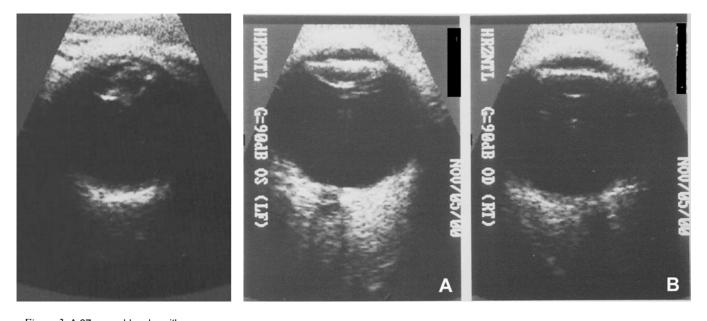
Ocular sonography of a 28-year old male, with a history of blunt trauma to the right eye 6 years earlier. He presented with clinical diagnosis of post-traumatic cataract of OD.
